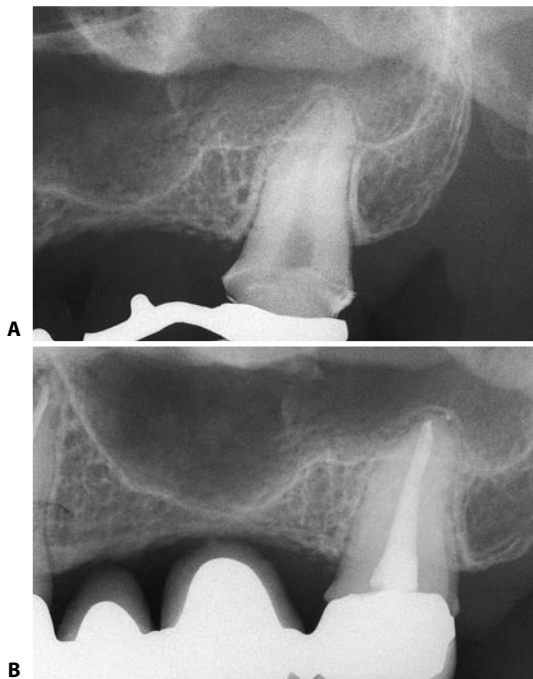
A. Preoperative radiograph of an upper left second molar with a single canal in a single root. B. One year after endodontic therapy.
